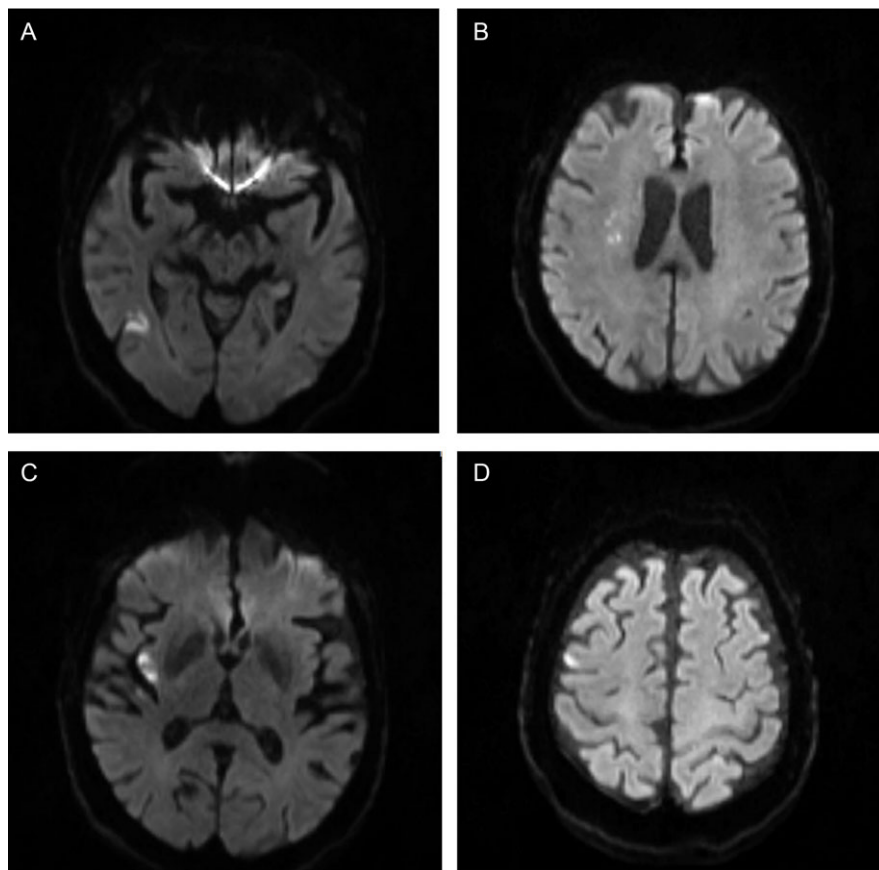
(A–D) Axial view of an MRI Brain showing multiple areas of focal diffusion restriction in the right MCA territory.
